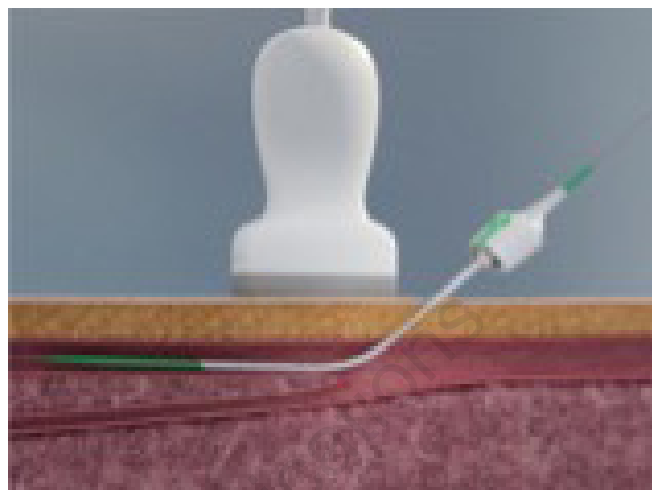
Deep introduction of the Angio-Seal VIP sheath. With ultrasound, the Angio-Seal VIP sheath is easily visualized in the superficial femoral artery.
